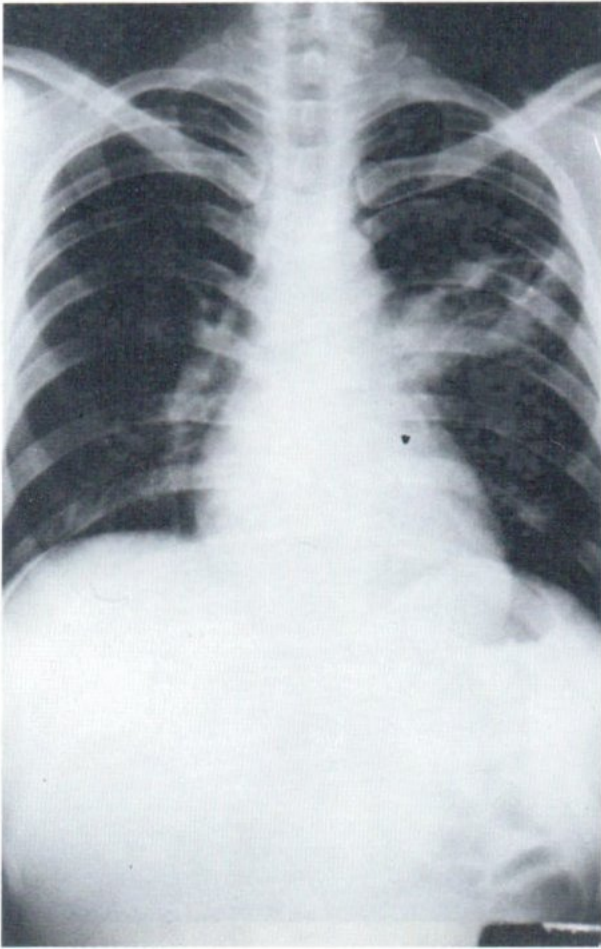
Chest radiograph shows patchy infiltrate with cavities in left upper lobe.
